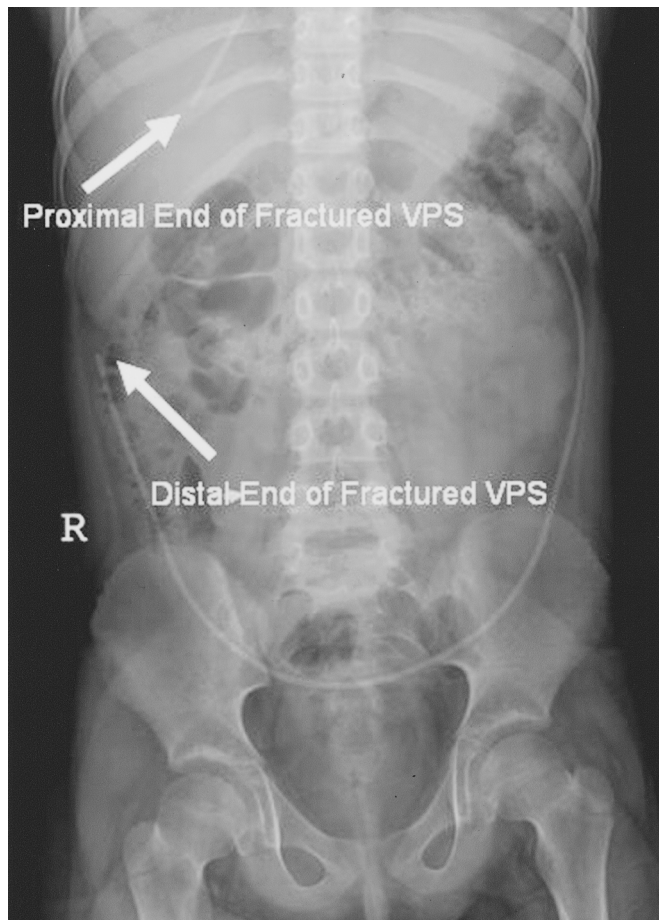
Abdominal radiograph demonstrating a ventriculoperitoneal shunt fracture with migration of the proximal catheter out of the peritoneum.
